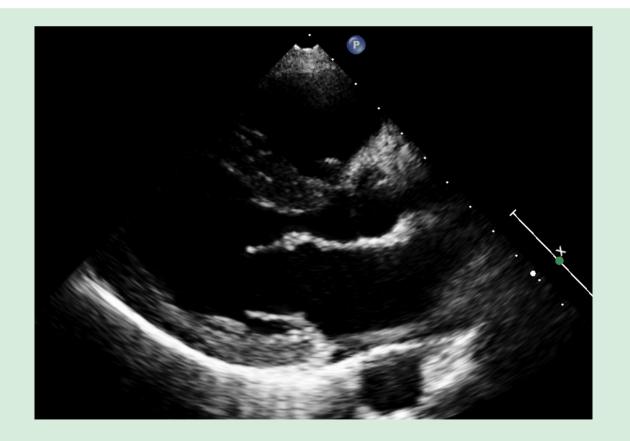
AE: Left Atrium, Ao: aorta, VE: left ventricle, VD: Right Ventricle, VM: Mitral Valve. 2D Echocardiography with parasternal longitudinal image (diastole) showing a structurally normal mitral valve with thin leaflets.
